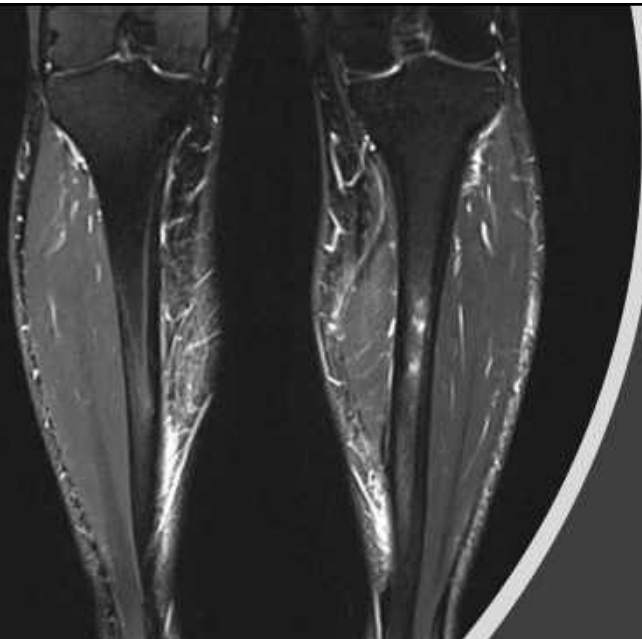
Fredericson classification for medial tibial stress syndrome on magnetic resonance imaging.
